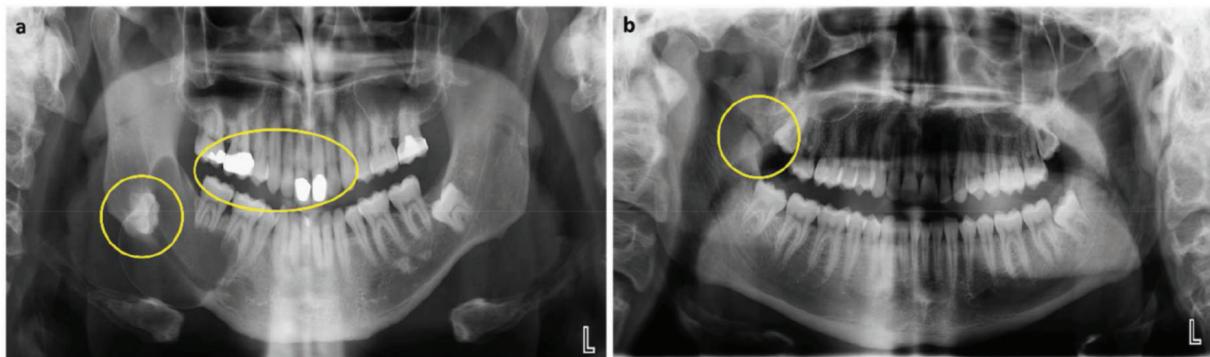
Radiograph of OPG (a) OPG of male patient, showing dental fillings, unerupted molar teeth; (b) Male, 20 with history of trauma with displaced fracture of the right coronoid process
